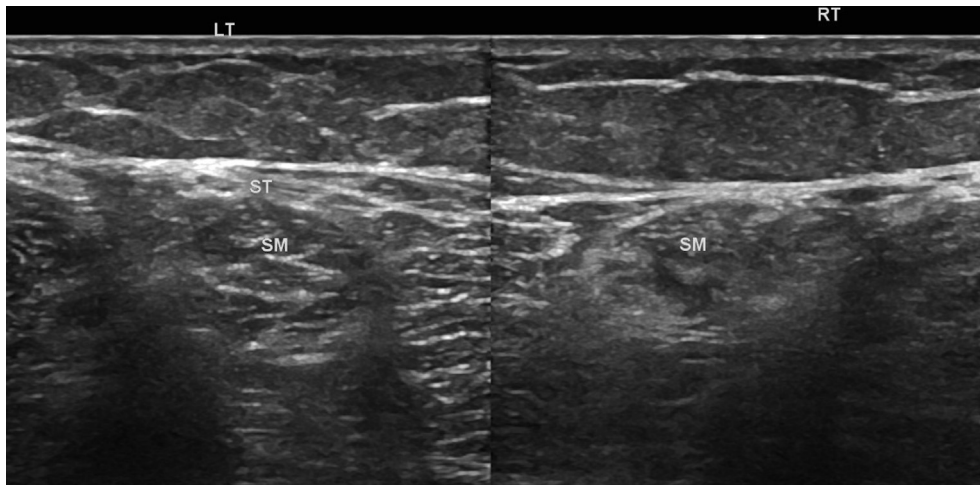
Shows ultrasonographic image of both knees (right operated). There is no evidence of regeneration in the operated limb.
